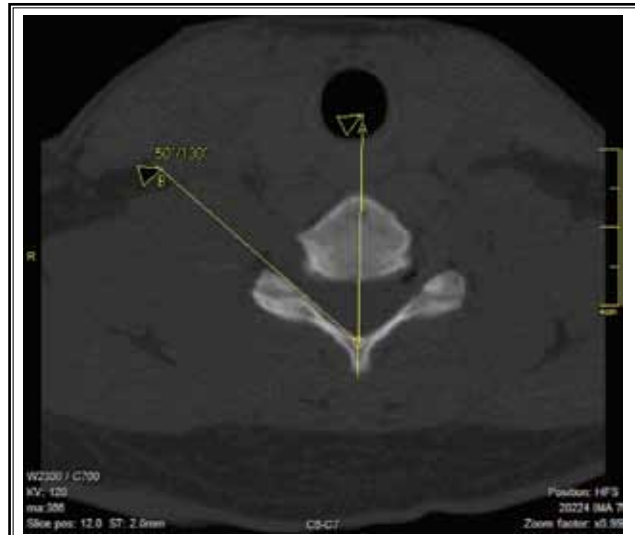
CT scan showing lines used to measure optimal angle of entry at vertebral/foraminal level.
